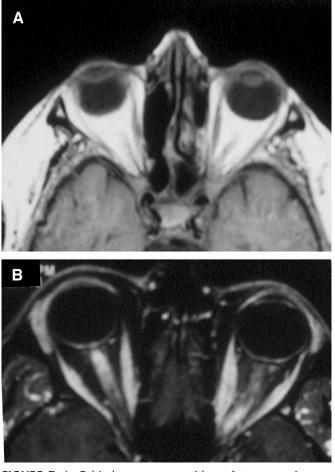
A, Orbital appearance without fat suppression on standard brain magnetic resonance imaging. B, Orbital appearance with fat suppression on orbital short τ inversion recovery sequence magnetic resonance imaging.
